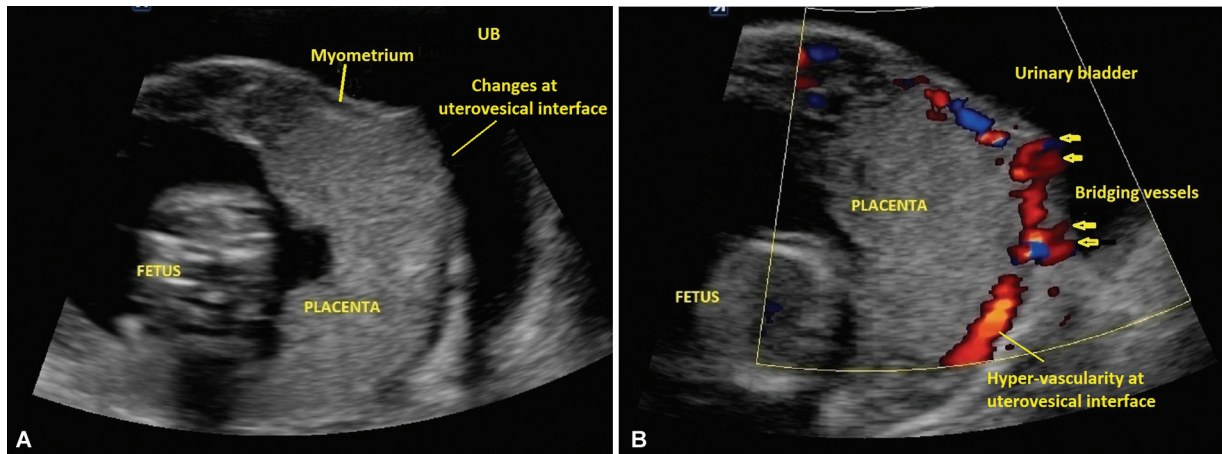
(A, B) A known case of CSP diagnosed at 7 weeks of gestation, follow-up (A) grayscale and (B) color Doppler images at 13 weeks and 5 days show several observations. The absence of myometrium and irregularities in the echogenic bladder line (arrow) is due to abnormal placental vasculature at the uterovesical interface (indicated by arrows). (B) depicts bridging vessels with the color Doppler, matching those seen in (A). CSP, cesarean scar pregnancy; UB, urinary bladder.
